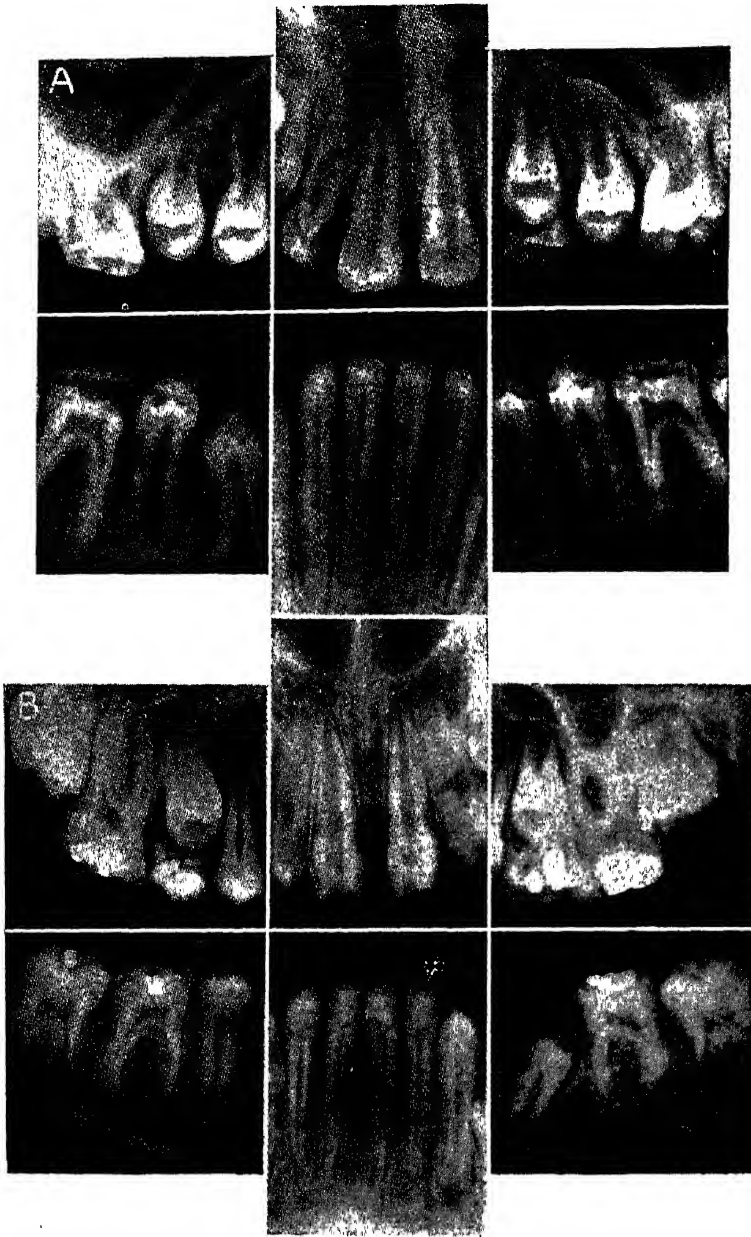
Intraoral roentgenograms of the incisor and molar areas of the same patients with congenital syphilis described in Fig. 22. Note the size and shape of some of the permanent incisors (except the upper lateral incisors) and the permanent first molars (see Fig. 22). (B. G. Sarnat and N. G. Shaw: *Am. J. Dis. Child.*)
